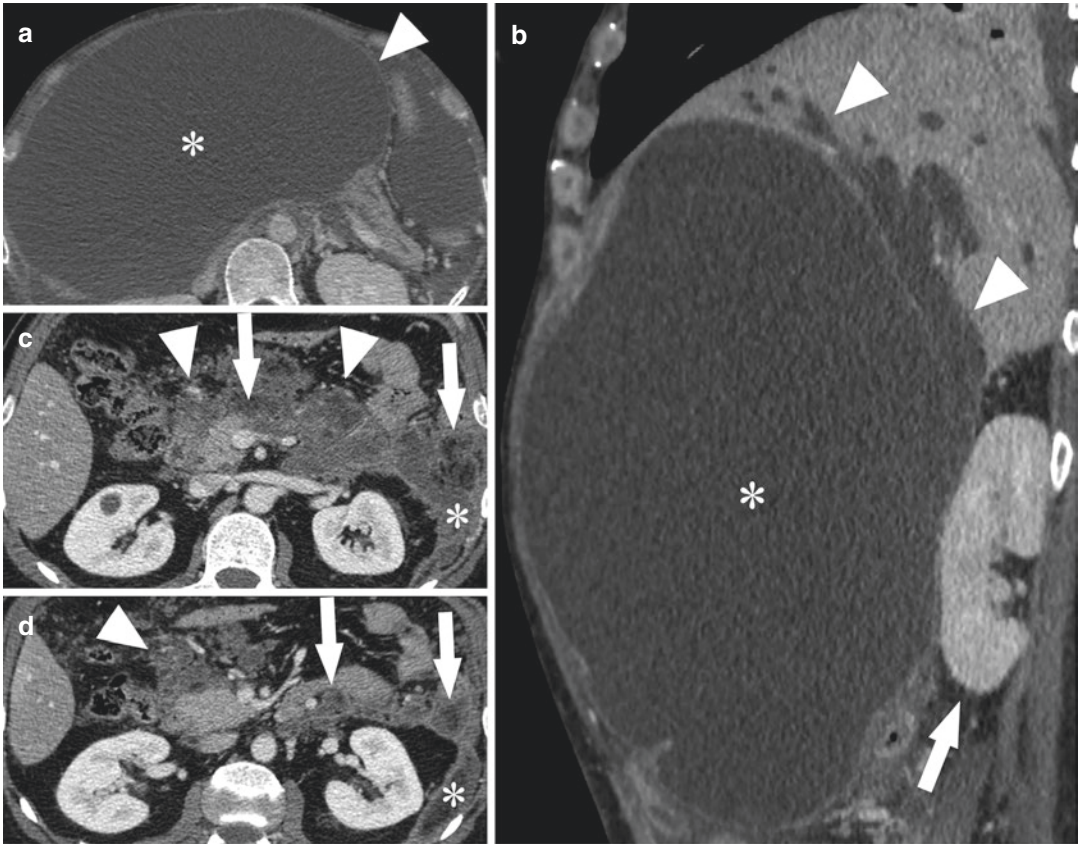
Pseudocyst and WON. (a) Pseudocyst in a 42-year-old man. Axial contrast enhanced portal venous phase CT image shows a huge homogeneous peripancreatic fluid collection (*) with no non-liquefied components and a thin enhancing wall (arrowhead). (b) Sagittal contrast enhanced portal venous phase CT image in the same patient shows the extent of the fluid collection (*) which compresses the liver determining marked biliary ductal
